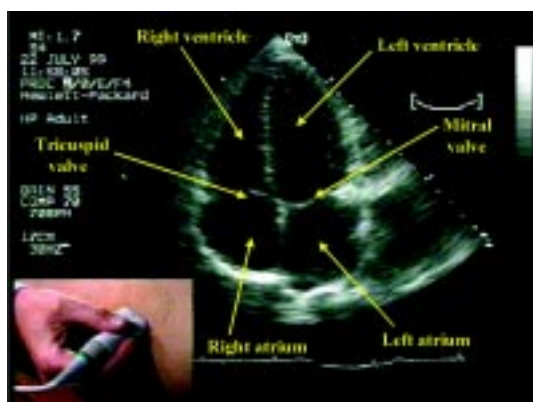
The classical apical four chamber cut of the heart.
